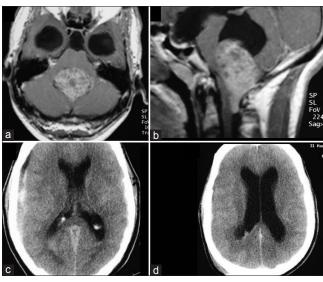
(a, b) Case 3, Contrast-enhanced MRI scan (axial and sagittal section) showing a large fourth ventricular tumor, ependymoma (c) Case 3, Postoperative CT scan showing right-sided SDH (d) Case 3, Follow-up CT scan showing completely resolved SDH
